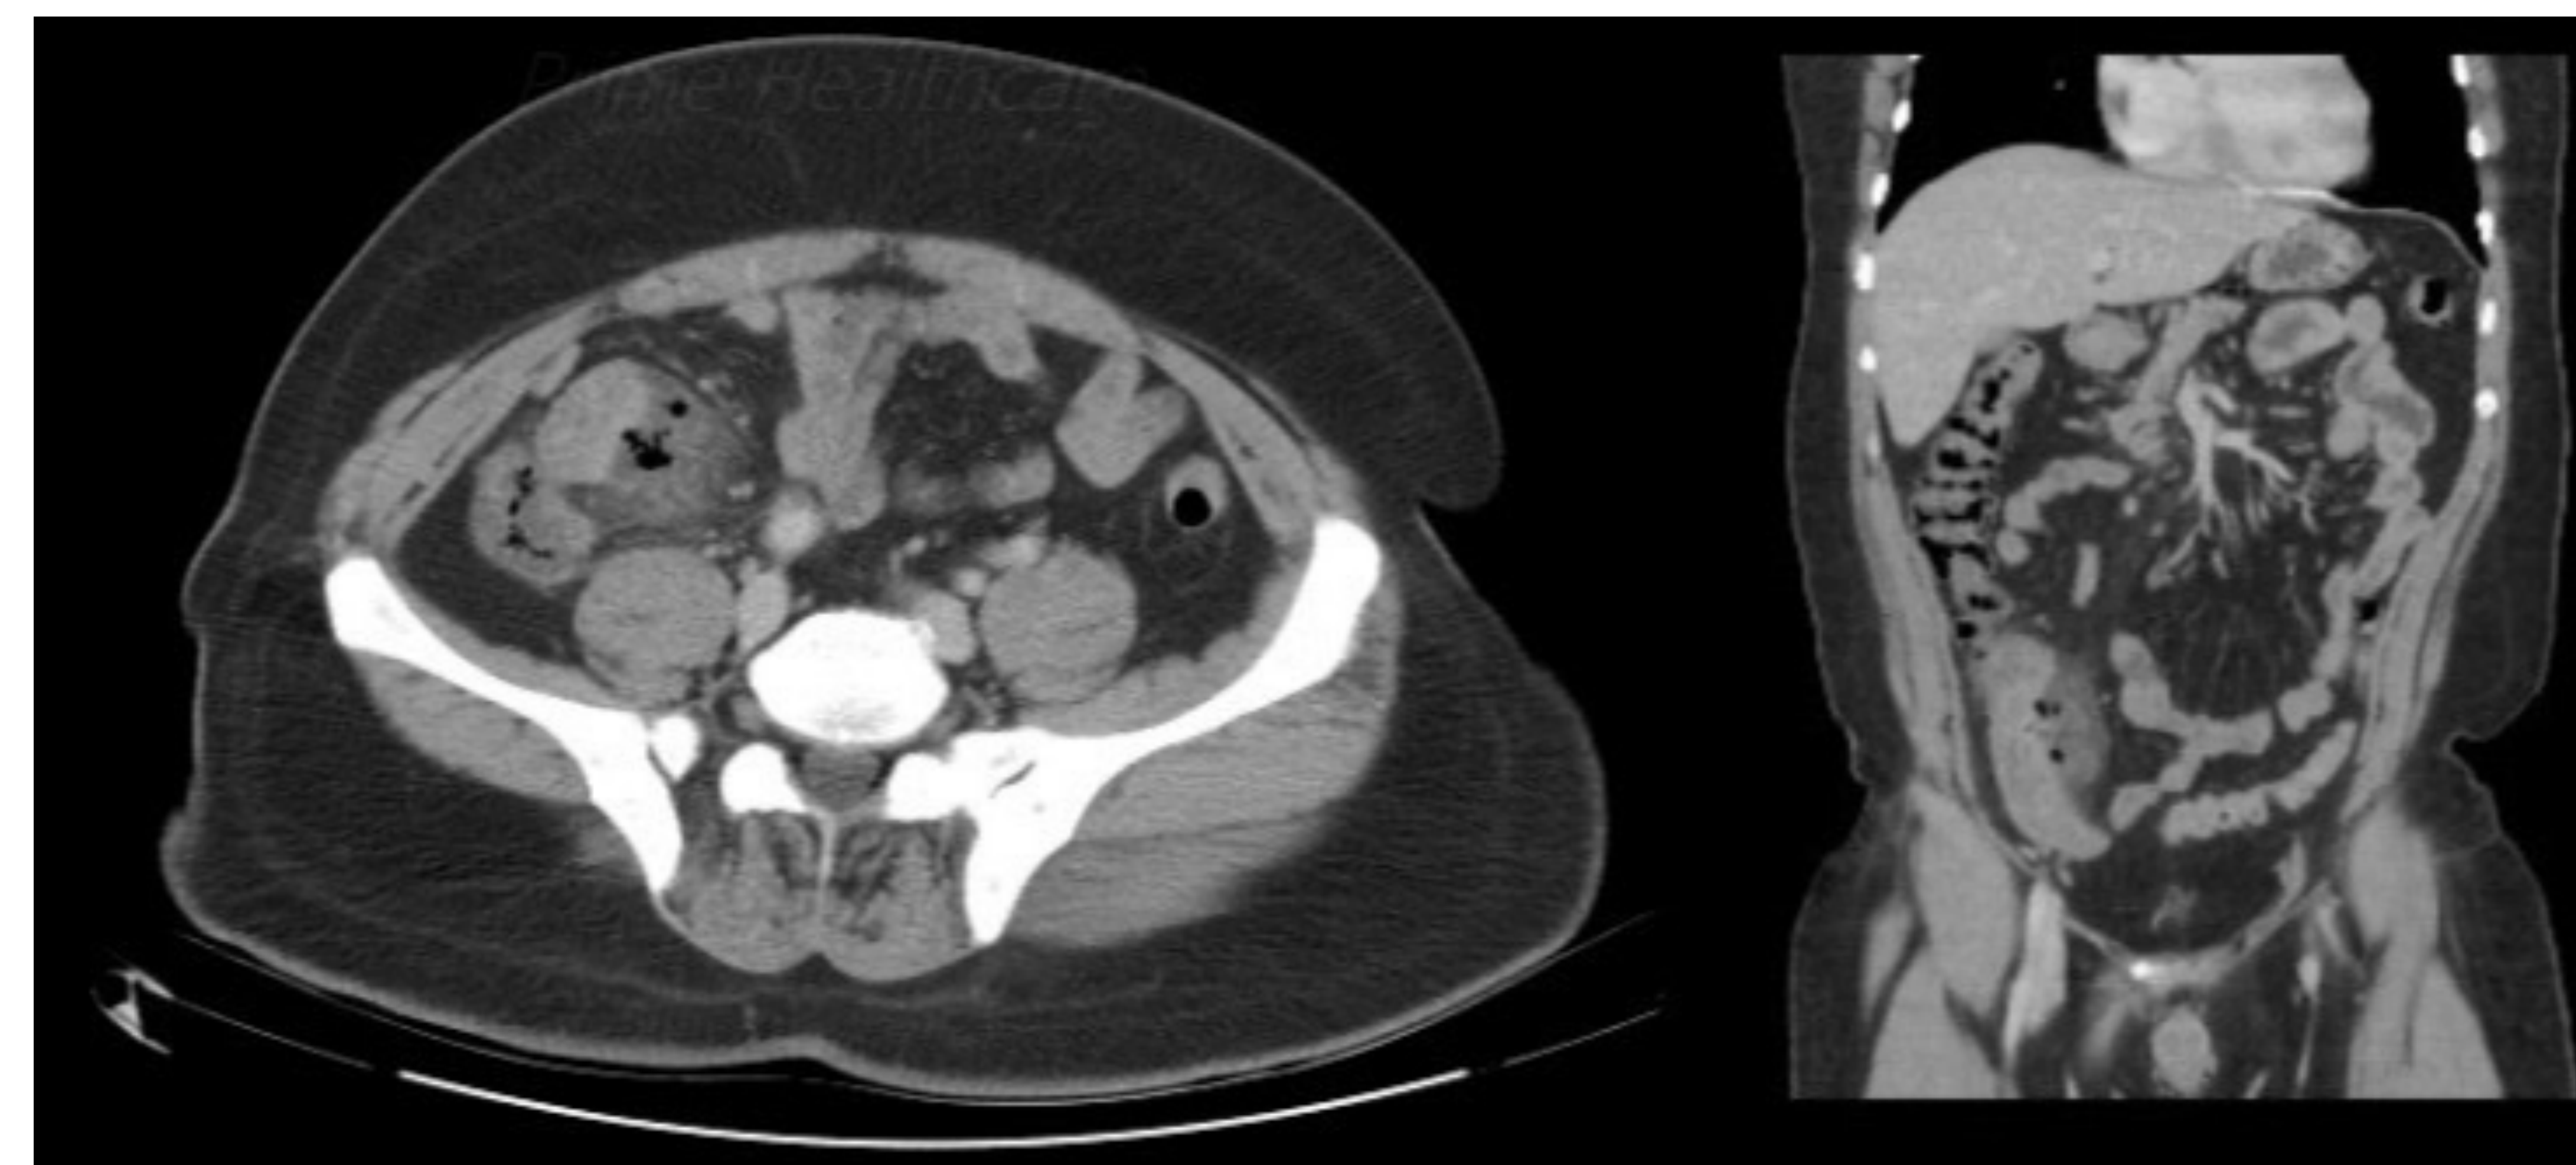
CT Abdomen Pelvis showing phlegmonous changes in the right lower quadrant with a small amount of extraluminal air with phlegmonous loop of terminal ileum.
